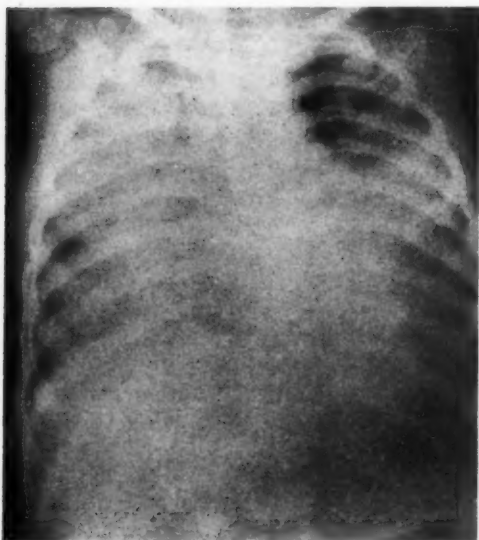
Case III. Chest radiograph of a 15-month-old child taken three hours after drinking an unknown amount of kerosene. Child was found coughing and gagging; cyanotic, dyspneic, and semicomatose. Death three-quarters of an hour later.
